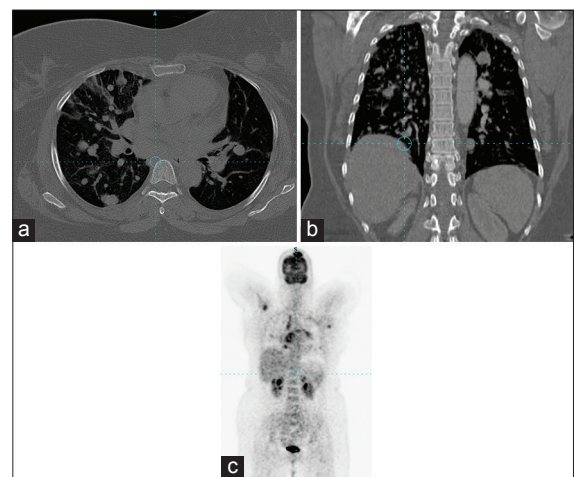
Axial (a) and coronal (b) slices of high-resolution computed tomography images of the chest demonstrate multiple bilateral randomly distributed metastatic nodules of varying sizes. (c) A positron emission tomography image showing hyper metabolic spots in the lungs, right supraclavicular lymph node and brain suggesting disseminated metastases
